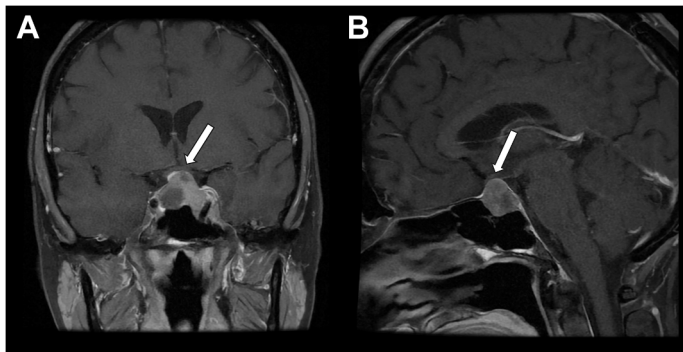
Pituitary macroadenoma extending into the suprasellar cistern and exerting mass effect on the inferior aspect of the optical chiasm. Coronal (A) and sagittal (B) post-contrast T1-weighted imaging showing a heterogeneously enhancing mass lesion contacting and elevating the left aspect of the optical chiasm (white arrow).
